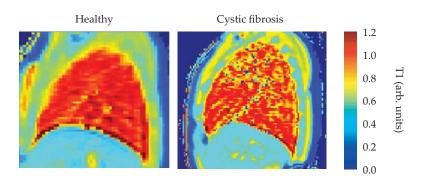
QUANTITATIVE T1 MRI MAPPING
